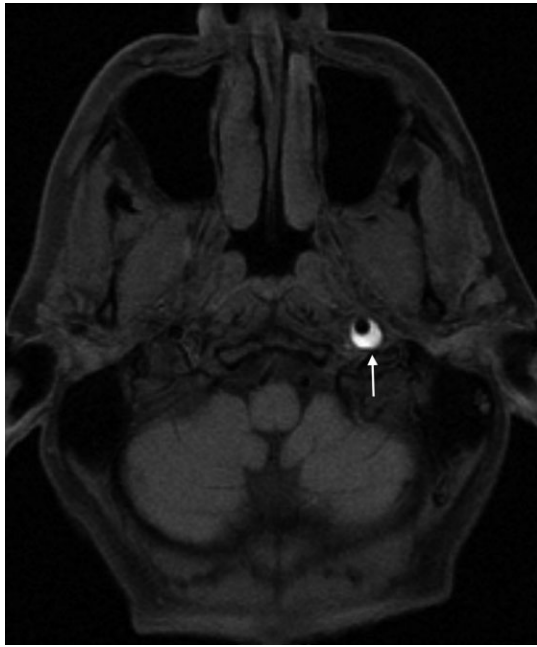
Carotid dissection. The T1-weighted magnetic resonance image, performed with fat suppression, shows a hyperintense crescent (arrow) beneath the adventitia of the left internal carotid artery. The high signal represents a subacute intramural hematoma. In this case, the caliber (flow void) of the vessel lumen is preserved.
